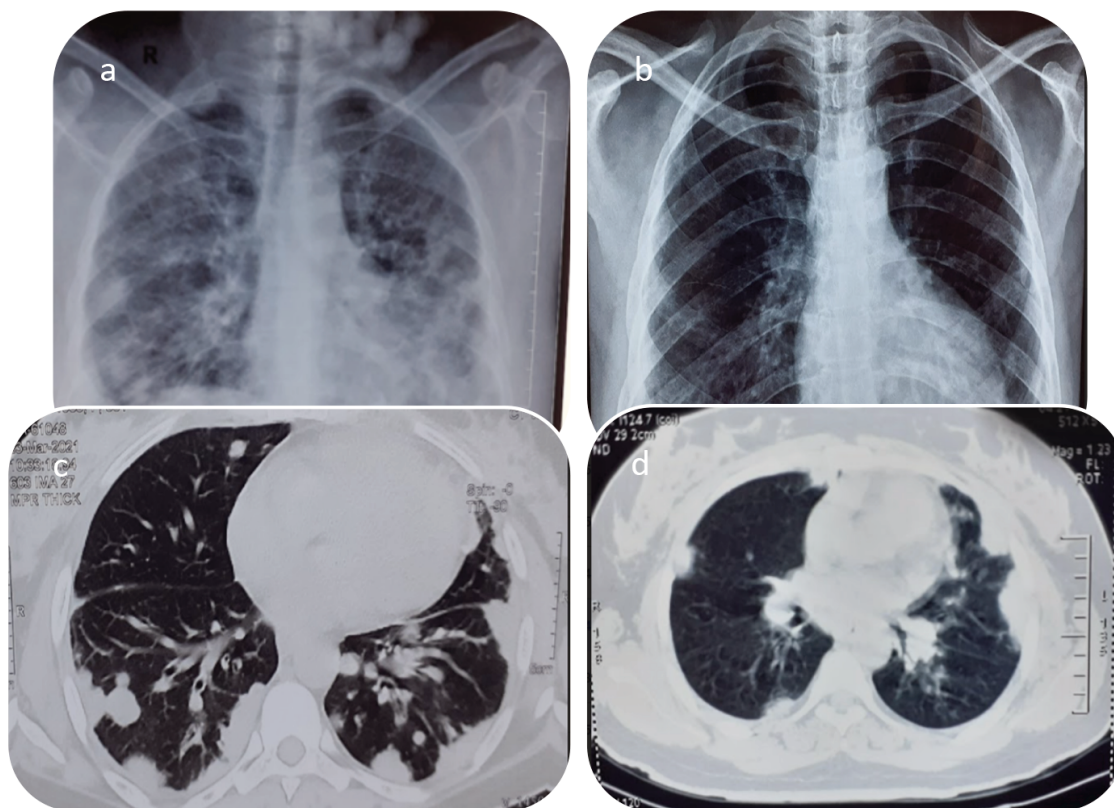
Case 1. Chest X-ray a) at presentation, b) after treatment; Computed Tomography (CT) of the thorax showing c) multiple nodules in bilateral lung, d) a decrease in the number of nodules after the treatment.
